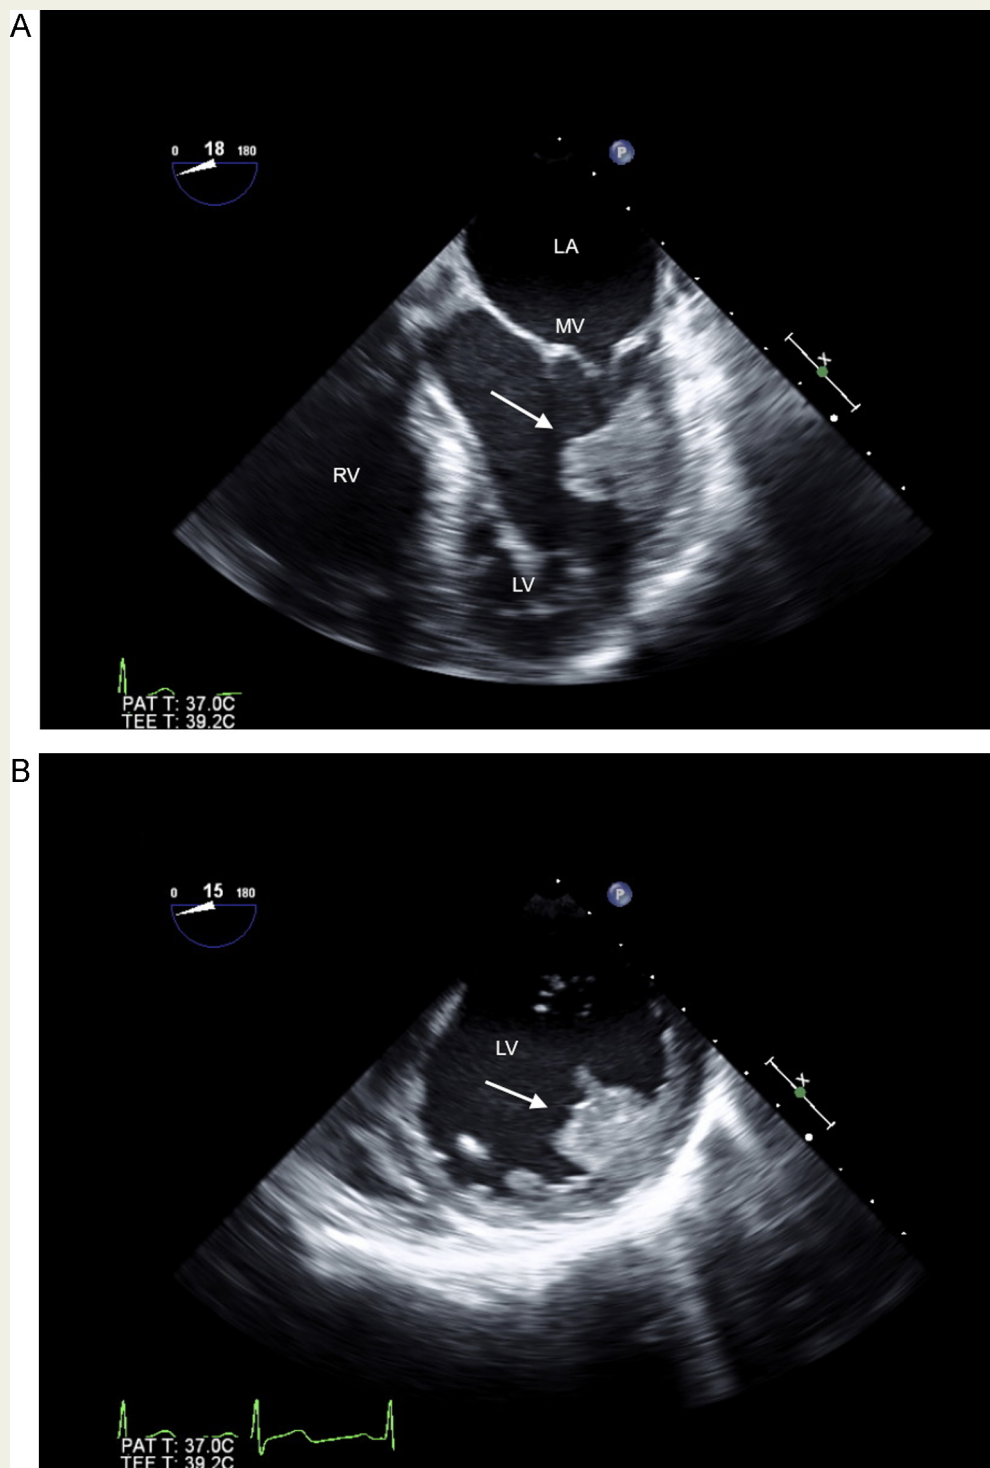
Large well-defined mass attached to the anterolateral papillary muscle (arrow) in the 5-chamber transoesophageal view of the left ventricle (A), and transgastric short axis view (B).
